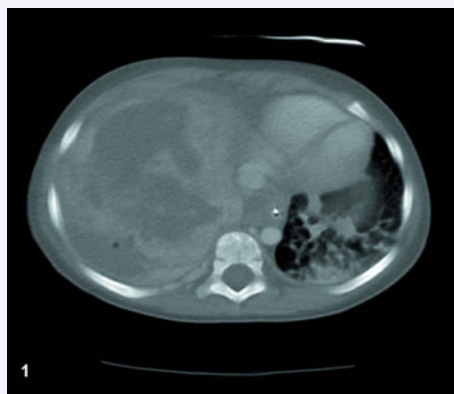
CT scan showed a large intraabdominal tumor occupying the right lobe of the liver.
